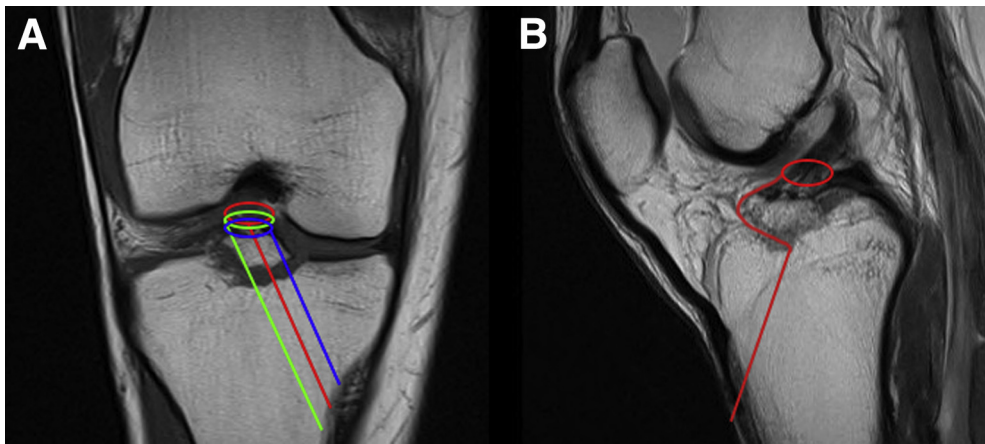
Preoperative magnetic resonance imaging scan of the right knee. (A) The anteroposterior image shows the suture attachments around the anterior cruciate ligament (ACL) and the medially directed tibial bone tunnels through which the anterior “lever” suture (red), medial suture (blue), and lateral suture (green) pass. (B) The lateral image shows the “lever” suture (red) attachment around the ACL, passing anterior to the fragment, and through the tibial bone tunnel, thereby reducing the avulsed fragment inferiorly and posteriorly.
